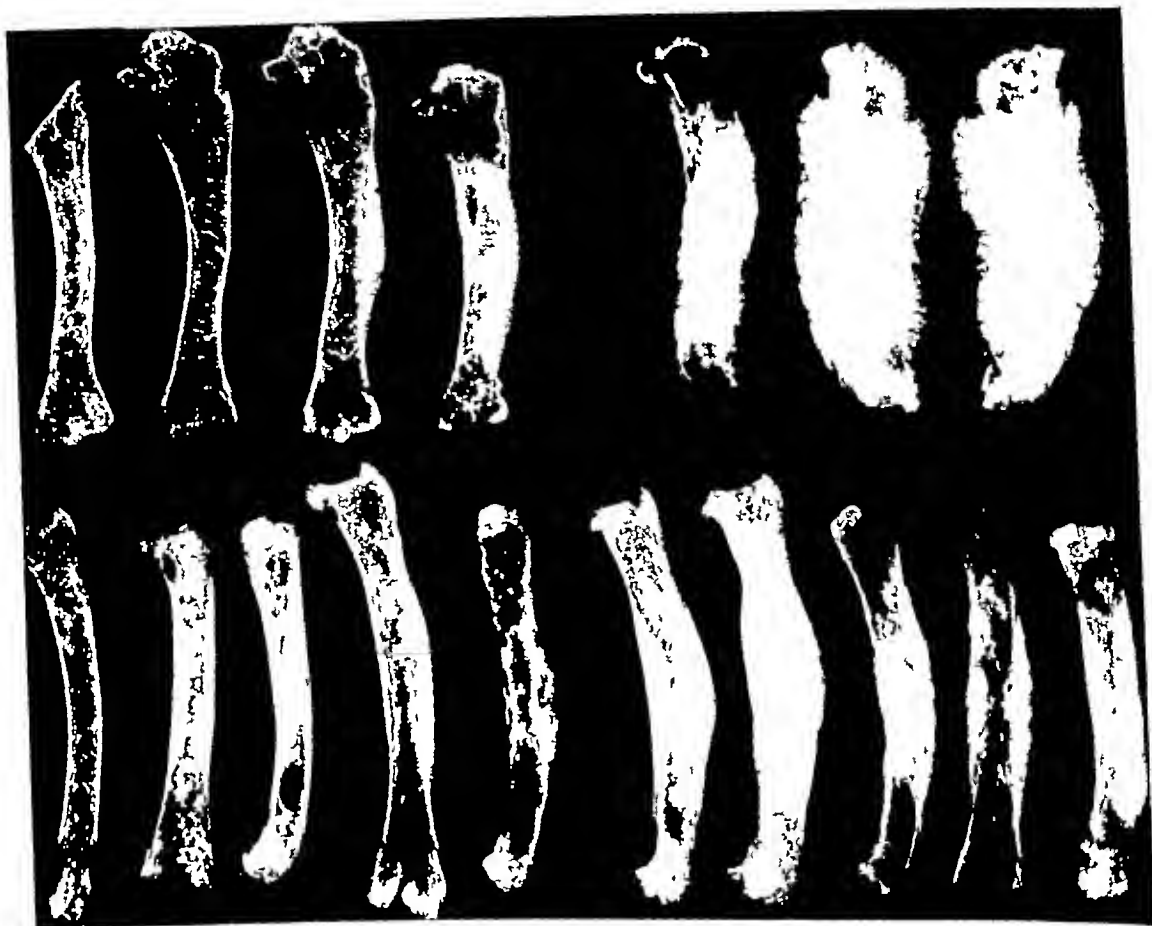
Roentgenograms of humeri (above) and femora (below) of osteopetrotic birds, normal bones on left.
